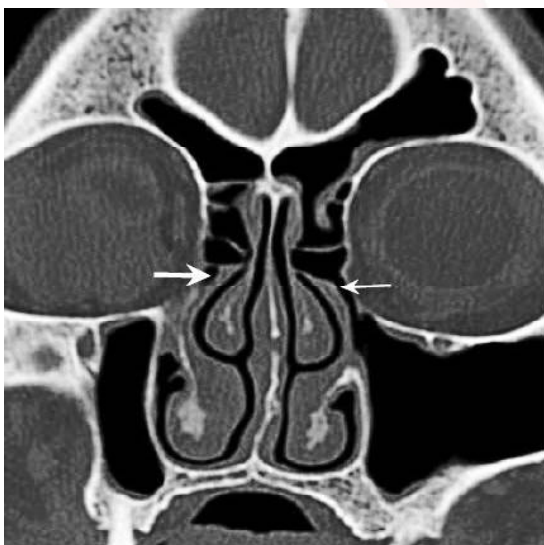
Coronal CT Showing Bilateral Retroverted Uncinate Process (Arrows)
